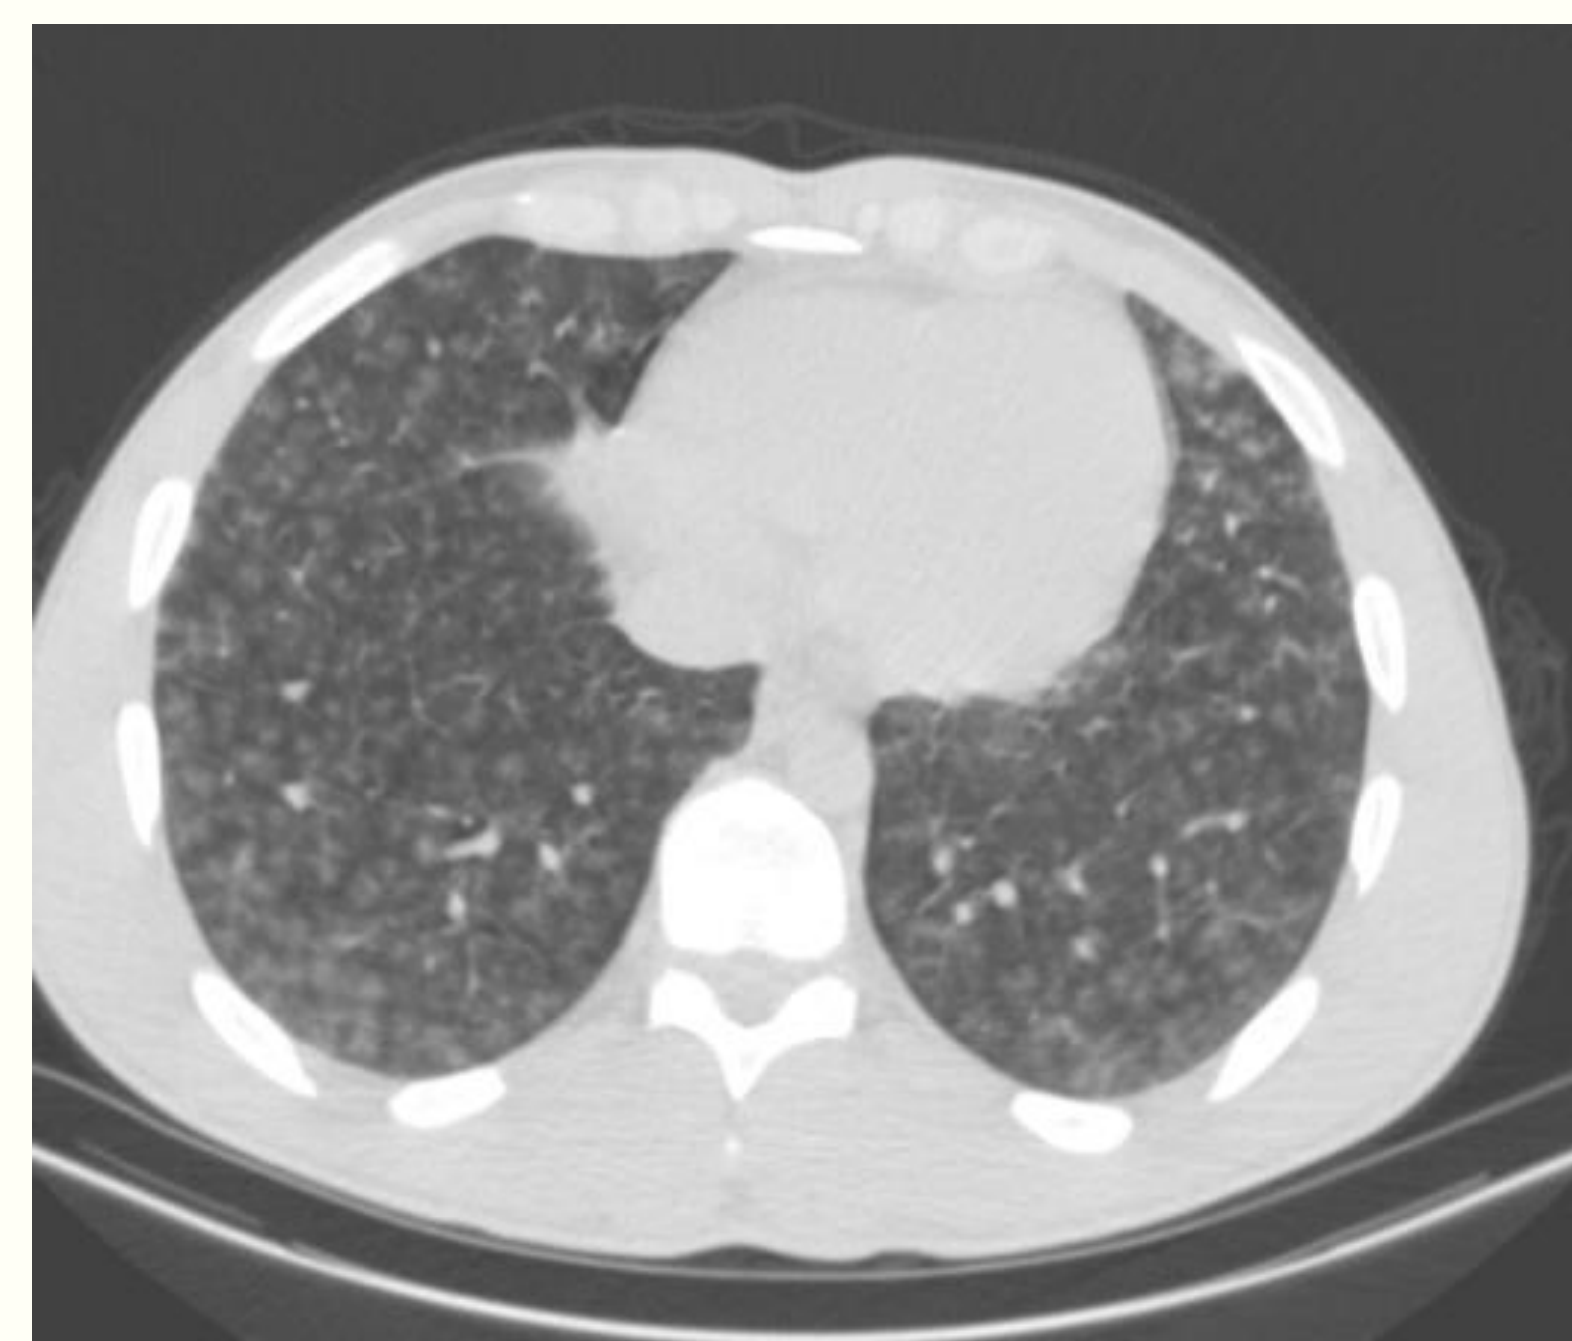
Admission Abd/Pelvic CT: Lung bases reveal innumerable bilateral centrilobular subcentimeter nodules, findings could be secondary to alveolar hemorrhage.
